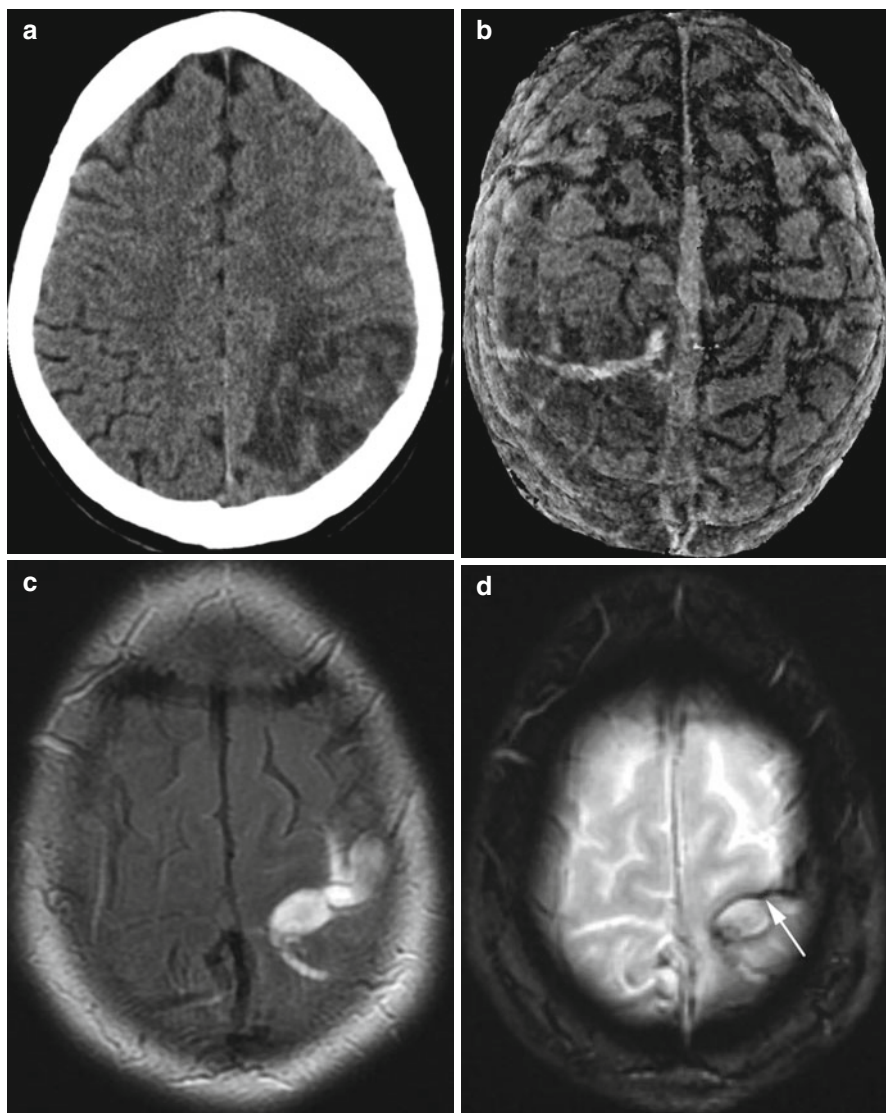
Cortical vein thrombosis. (a) CT demonstrates a cortically based infarction in the left parietal lobe. (b) 3D reconstruction shows a hyperdense, thrombosed cortical vein (“cord sign”) which is difficult to appreciate on axial images. FLAIR (c) and gradient recalled echo (d) ($T2^*$) images in a different patient demonstrate FLAIR hyperintensity in the region of the left precentral gyrus; $T2^*$ images show low signal in the thrombosed cortical vein (*arrow*)
